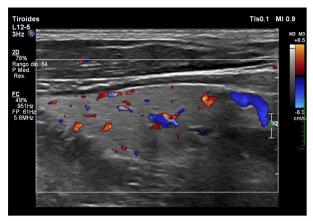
Thyroid ultrasound. The thyroid gland is slightly enlarged. Thyroid tissue is heterogeneous with multiple hypoechoic micronodular areas. Vascularity is diffusely increased.
